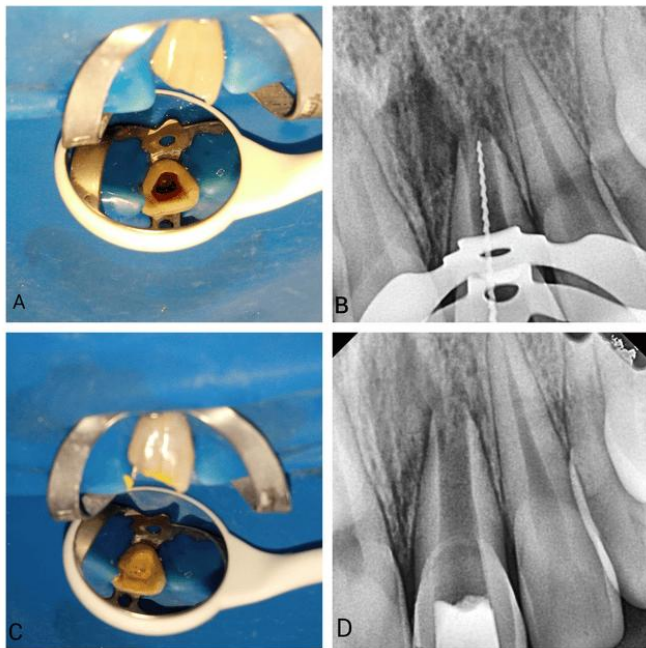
A: Access opening done ; B: Working Length Determination ; C: Triple Antibiotic Paste(TAP) as intracanal medicament ; D: Intraoral periapical radiograph after 4 weeks of placing TAP as intracanal medicament
